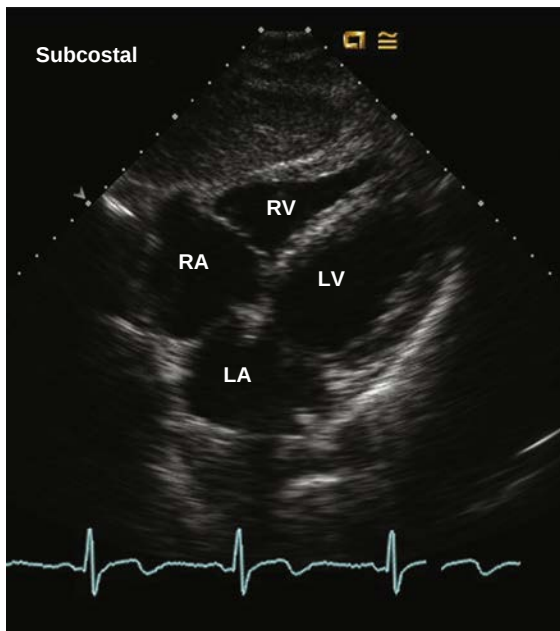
Subcostal 4-chamber view. This view is useful for evaluation of RV and LV function. This view also is best for evaluation of the atrial septum because the ultrasound beam is perpendicular to the septum from this transducer position.
